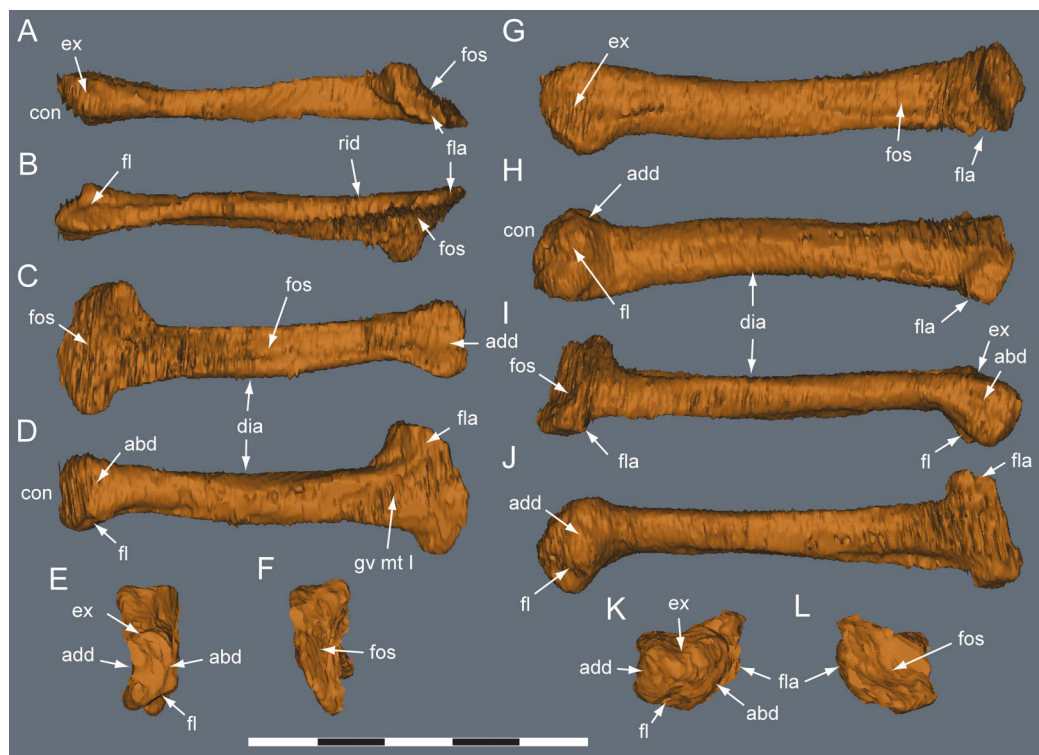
Diluvicursor pickeringi* gen. et sp. nov. holotype (NMV P221080), CT models of right metatarsals II–III. A–F, mt II in: (A) dorsal; (B) plantar; (C) lateral; (D) medial; (E) distal; and (F) proximal views. G–L, mt III in: (G) dorsal; (H) plantar; (I) lateral; (J) medial; (K) distal; and (L) proximal views. Abbreviations: abd, abductor surface/groove; add, adductor surface/groove; con, condyle; dia, diaphysis; ex, extensor groove or surface; fl, flexor groove or surface; fla, flange; fos, fossa; gv mt I, groove for metatarsal I; rid, ridge. Scale bar equals 50 mm.
